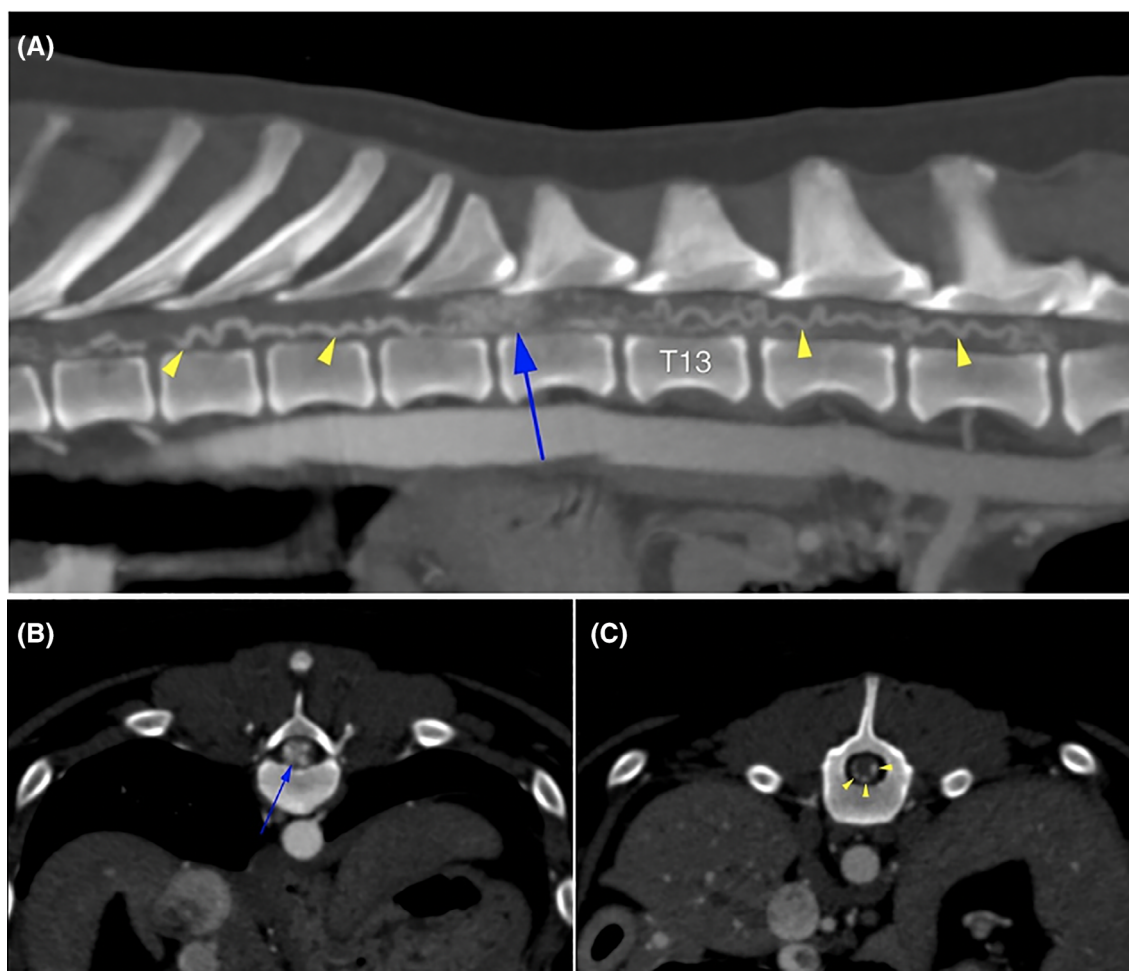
Sagittal, A, and transverse, B,C, reconstructions of a late arterial-phase computed tomography angiogram (CTA) of the thoracic spinal cord. Multiple, distended, tortuous, anastomosing, intradural extramedullary vessels are observed around the periphery of the spinal cord (arrowheads). An intramedullary focus at T11 to T12 represents a complex vascular plexus, formed of innumerable small anastomotic vessels, with strongest enhancement noted during the arterial phase (arrow)
